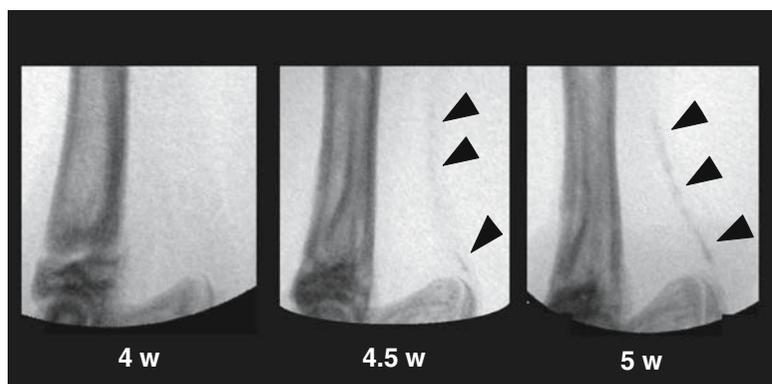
Early stage of ectopic ossification in *ttw*. The lateral radiograph (soft X-ray) of the Achilles tendon shows progression of the ectopic calcification/ossification (arrowheads). The lesion progresses along the substance of the tendon and merges with the bone
